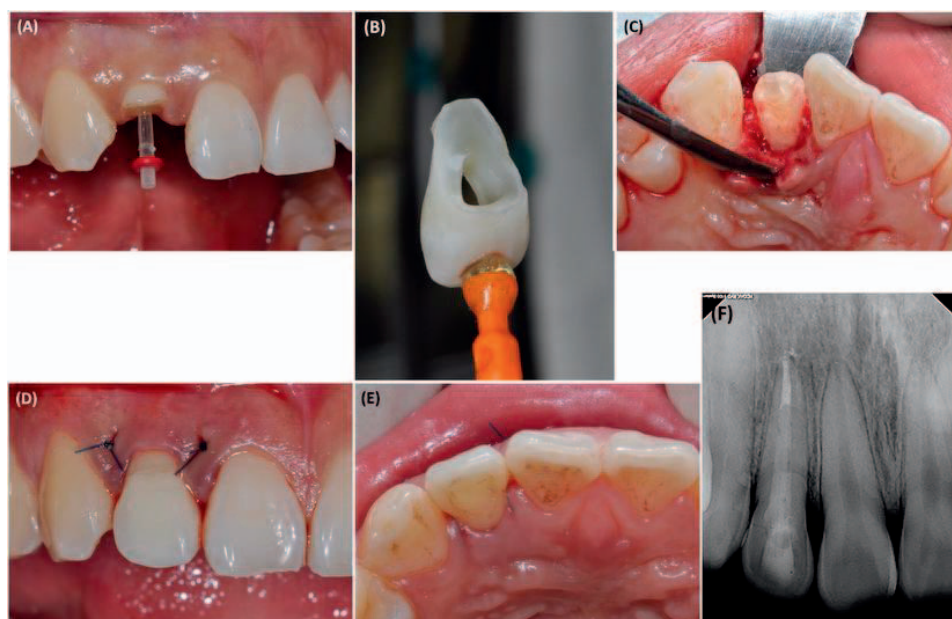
(A) A fiber post was selected within the post space of tooth #7 after root canal treatment. (B) An access hole was prepared on the palatal surface of the fractured fragment. (C) A palatal flap was raised, and an osteotomy was performed on the palatal side. (D, E) After reattachment and flap suturing and (F) intraoral radiograph after reattachment.
